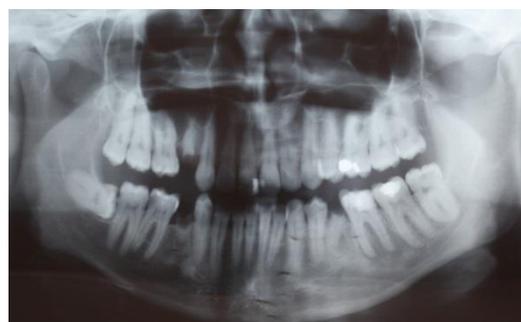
Panoramic X-ray showing tooth 38 in a vertical position, near the area of the mandibular channel, and tooth 48 in a horizontal position.
